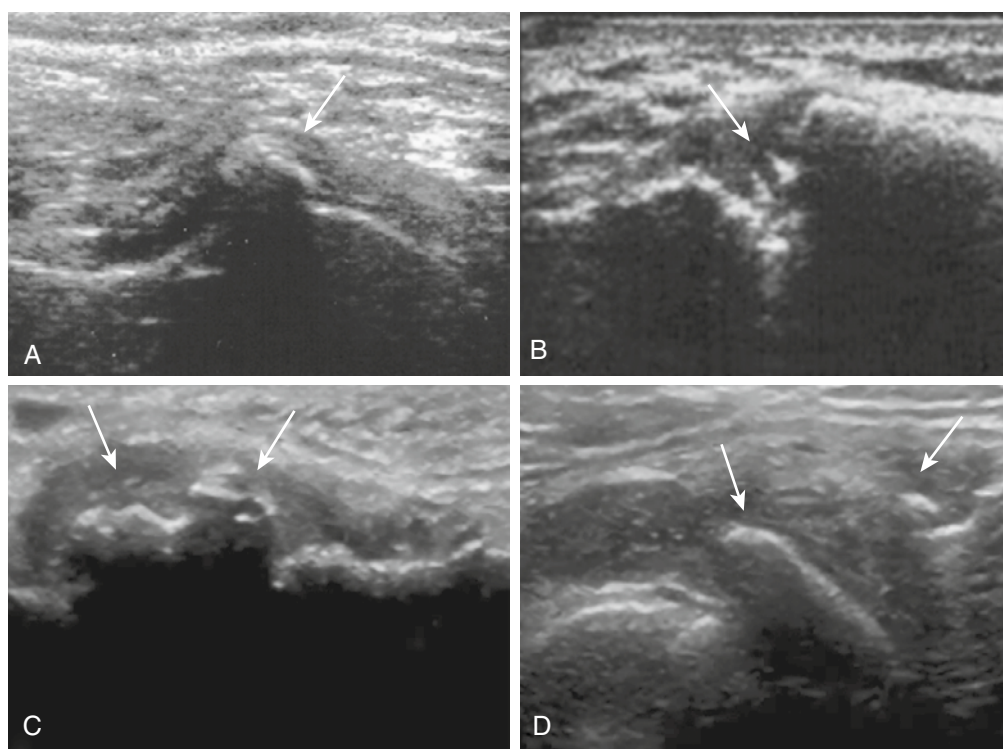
Osteoarthritic joints are evaluated with ultrasound. The 12-MHz images demonstrate osteophytes (*arrows*) with different sizes and morphology in the glenohumeral joint (A), acromioclavicular joint (B and D), and first metatarsophalangeal joint (C).
